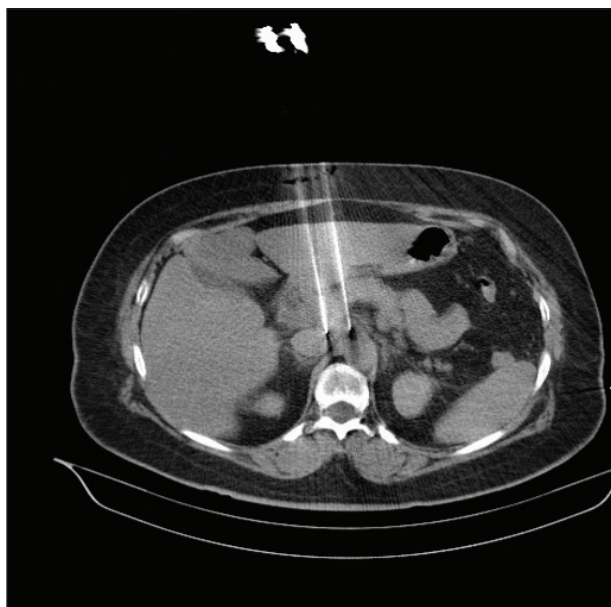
A CT scan showing IRE of the pancreas.
